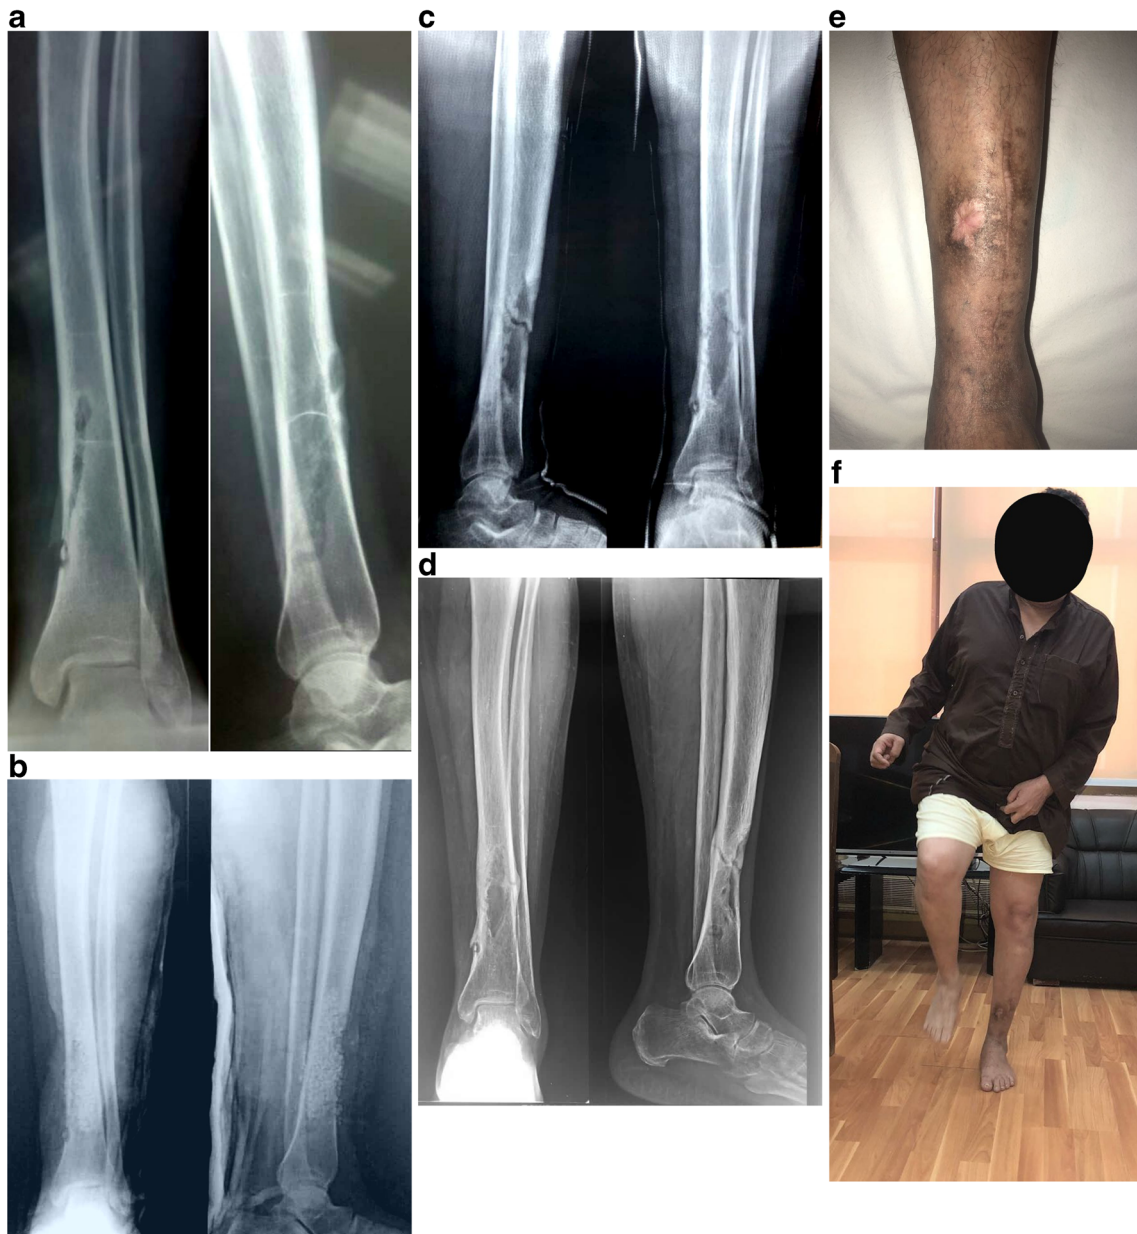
The same patient shown in the demonstration of operative technique in Fig. 1. a The pre-operative X-rays that show previous bone debridement with incomplete excision of the sequestrum resulted in failure with recurrent infection. b The immediate post-operative X-rays with the pellets filling the defect. c Six months post-operative X-rays showing tibial fracture with the whole CaSO_4 pellets dissolved with minimal
